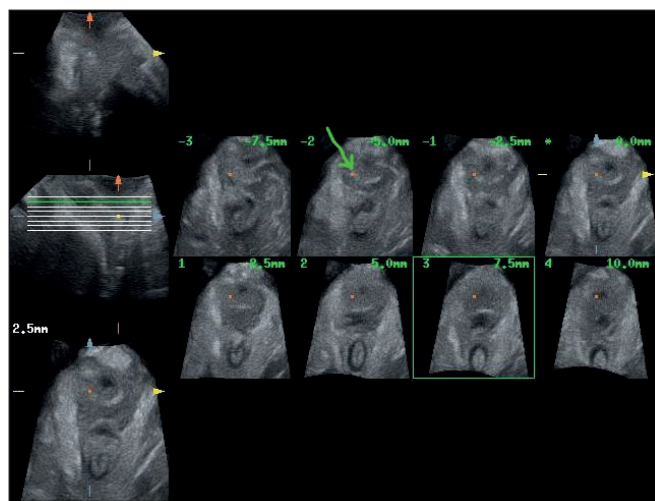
Tomographic ultrasound image of levator ani muscle avulsion (green arrow).
